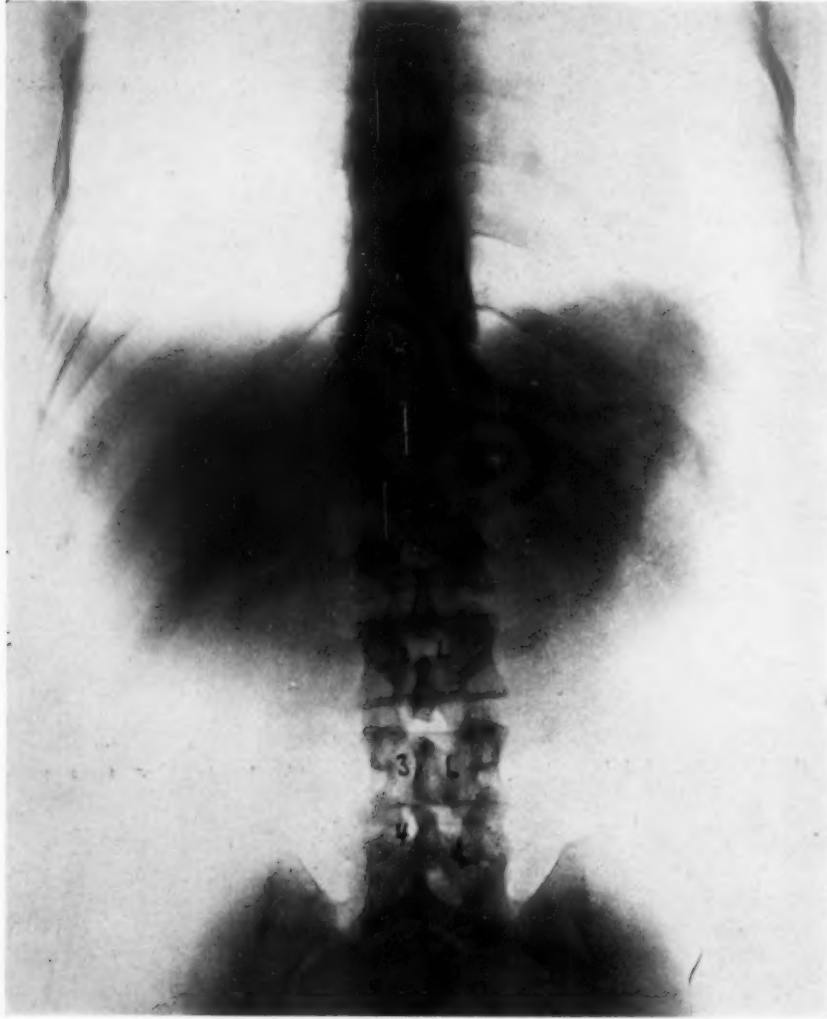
Appearance of the fifth lumbar vertebra when the central rays of the X-ray tube pass through the dorsal region. All that we see of the fifth lumbar is its posterior arch. Note the laminae, a, and the spinous process, b. The body of the fifth lumbar is not seen nor is the intervertebral space between the body of the fifth and the sacrum visible. When the tube is held lower down a part of the body of the fifth lumbar is brought into view. The radiogram of the fifth lumbar vertebra presents many variations between the extreme view shown in this picture and that shown in figure 1, dependent upon the location of the X-ray tube.
